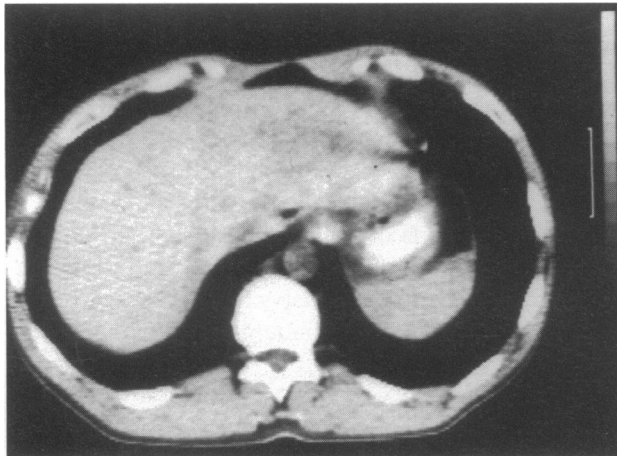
(A) Normal thoraco-abdominal CT scan showing linear air shadow around the liver.
